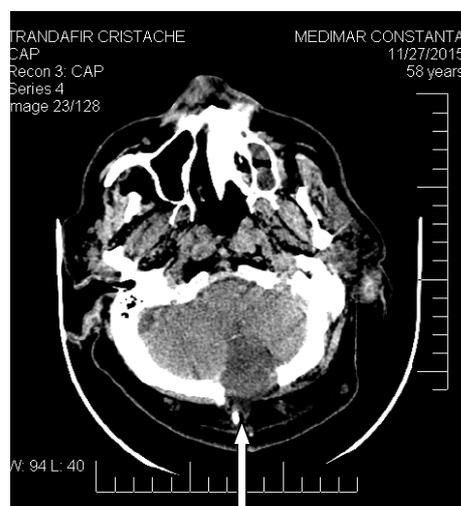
Postoperative Control. Cranial CT scan with contrast: Total resection of the tumor and evacuation of the haematoma (white arrow)
